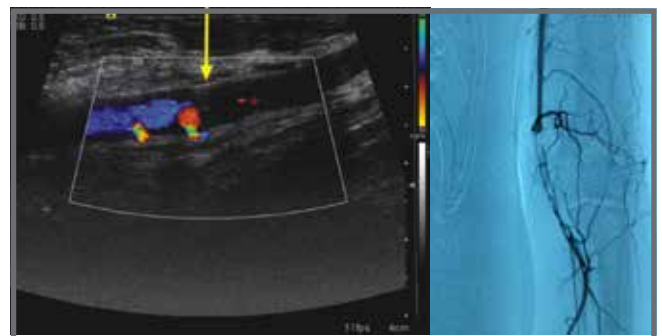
Acute occlusion (embolism) of brachial artery. A. Ultrasonography; B. Angiography (arrows)
